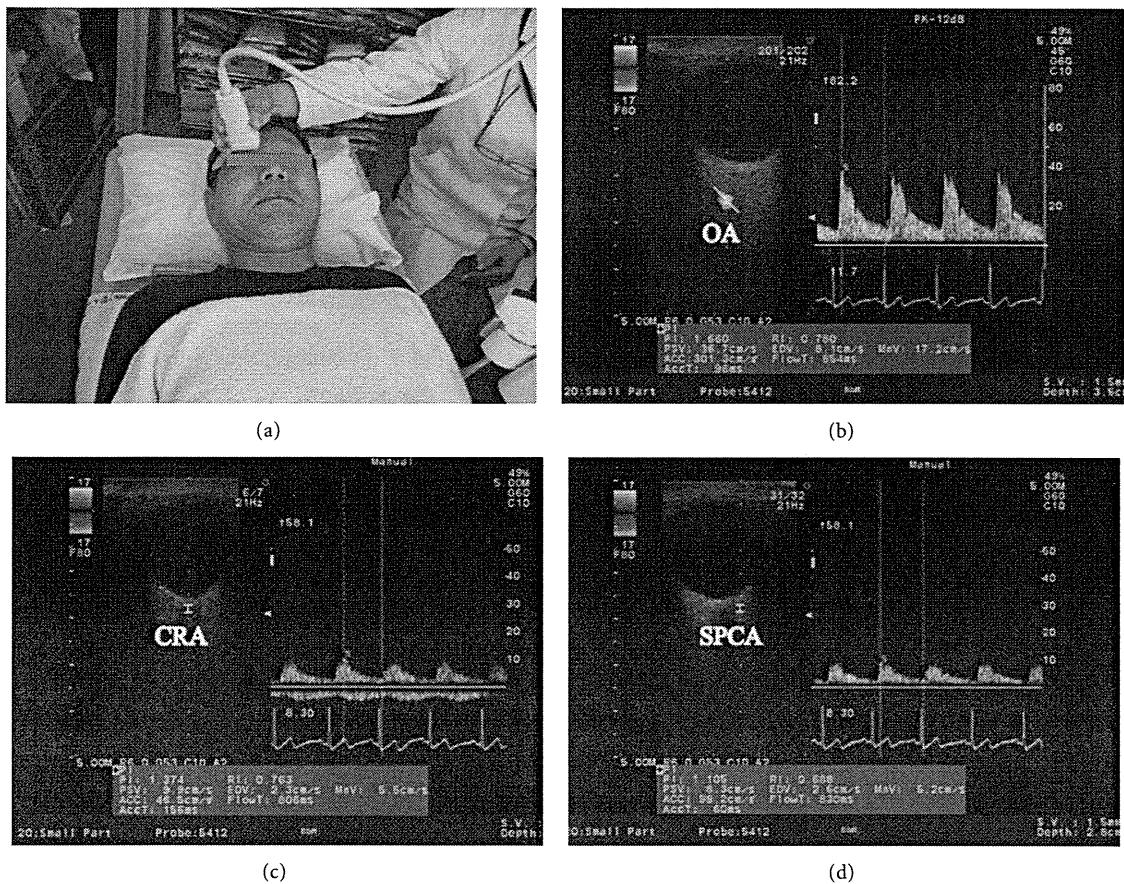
(a) Ultrasound measurement of retrobulbar arteries. 13 MHz linier transducer is attached on the eyelid. Horizontal scans by CDI through the ocular globe showing the (b) ophthalmic artery (OA), (c) central retinal artery (CRA), and (d) temporal short posterior ciliary artery (SPCA). Left: image of the vessel and the position of the artery tracking. Right: Doppler flow and flow velocity (b, c, and d).
